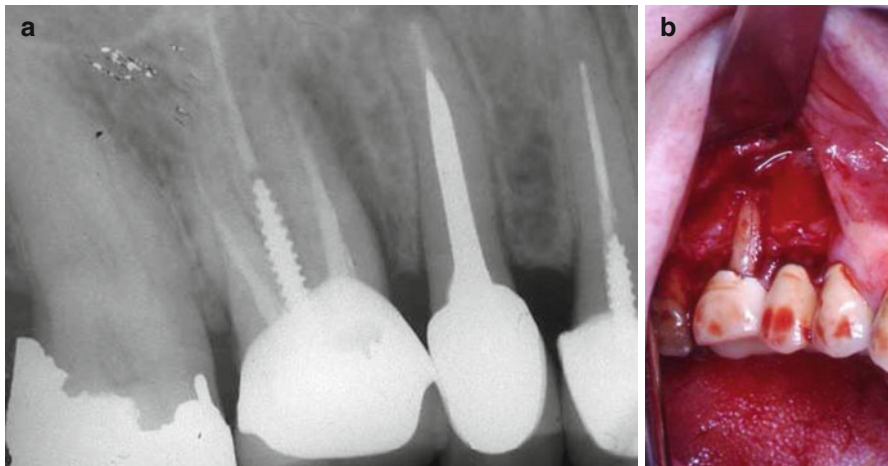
(a, b) Patient's chief complaint in this case was "I have an abscess that comes and goes for nearly a year." The tooth was endodontically treated 4 years earlier and a crown placed. Upon examination, a 10 mm probing defect was measured in the mesiobuccal aspect. The radiograph (a) shows a previously treated maxillary first molar and a large lateral radiolucency along the mesio-buccal root. Since there was no sinus tract and VRF diagnosis was inconclusive, a surgical flap procedure was performed (b). A complete bony dehiscence can be seen which was the result of a long-standing inflammation in the area facing the fracture (Courtesy Prof. A. Tamse)
